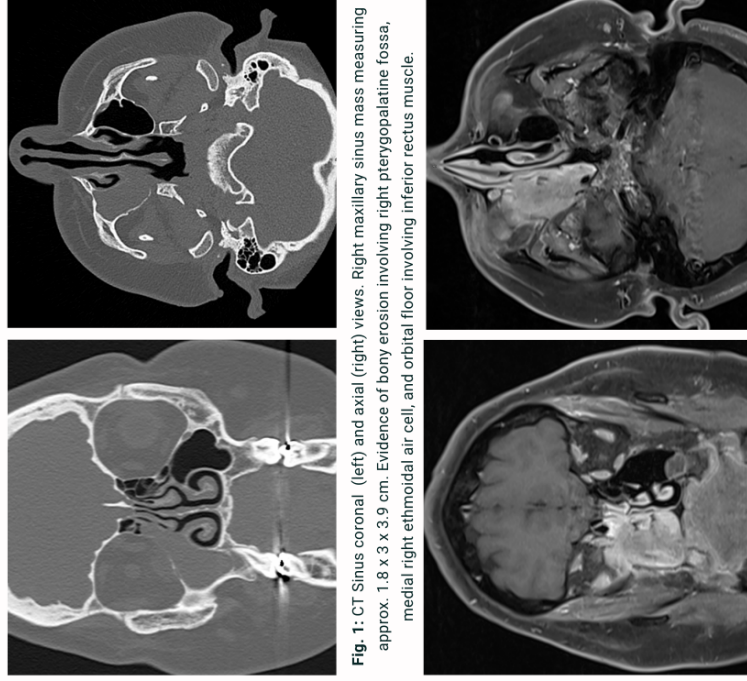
CT Sinus coronal (left) and axial (right) views. Right maxillary sinus mass measuring approx. 1.8 x 3 x 3.9 cm. Evidence of bony erosion involving right pterygopalatine fossa, medial right ethmoidal air cell, and orbital floor involving inferior rectus muscle.
